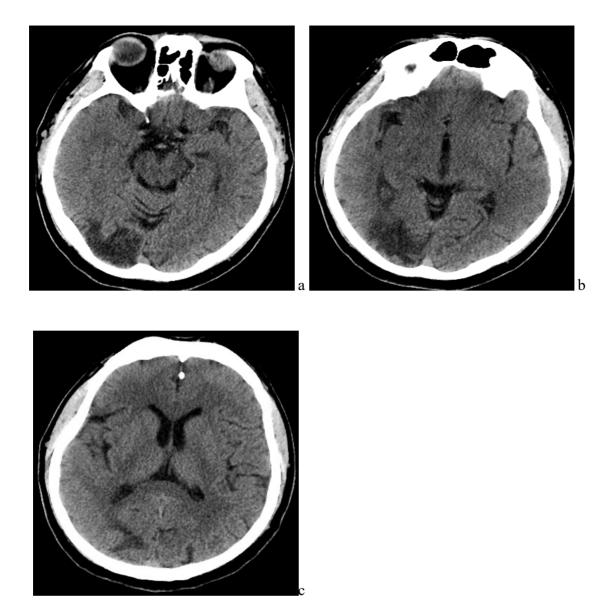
CT scan of the brain.
